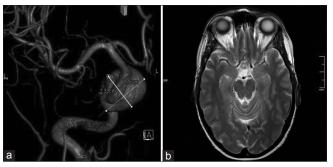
(a) Cavernous segment aneurysm pre-stenting. (b) Follow-up MRI after 1 year
